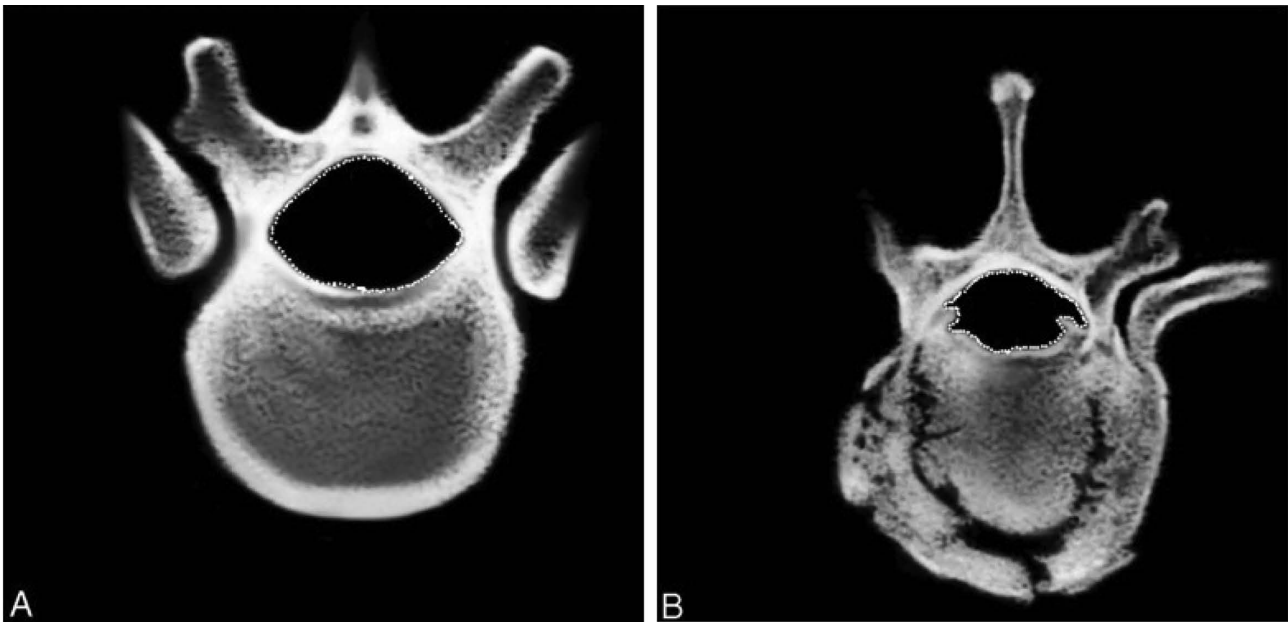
Transaxial CT showing direct measurement of the cross-sectional area (CSA) of the canal at adjacent levels (A) and at the level of injury (B) using an electronic digitizer.
